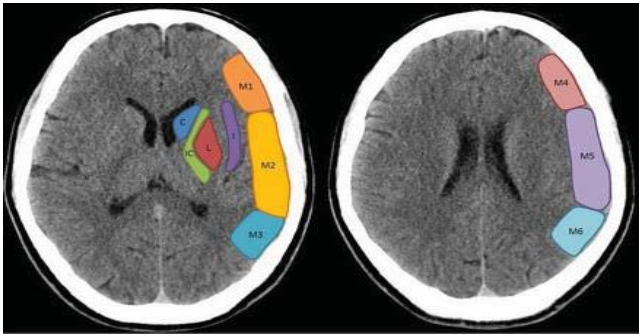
The ASPECTS score with its different regions C : caudate, L : lentiform, IC : Internal Capsule, I : Insula, M1 : anterior MCA cortex, M2 : MCA cortex lateral to insular ribbon, M3 : posterior MCA cortex, {M4, M5, M6} : anterior, lateral and posterior cortex respectively 2 cm overhead {M1, M2, M3}.[18]
